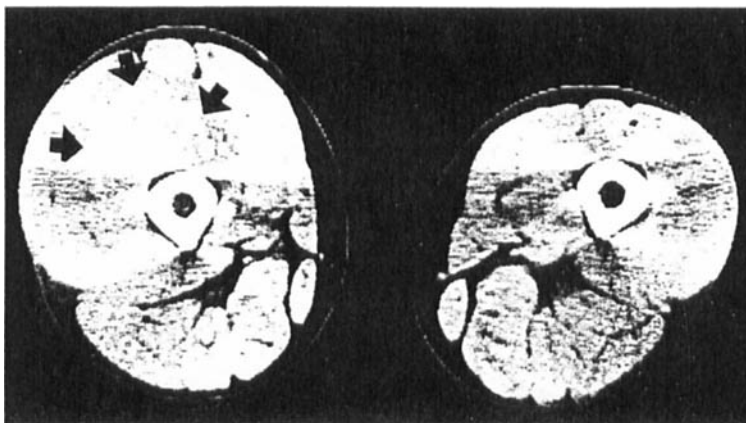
Case 1. CT 19 hours after the trauma. Hematoma in the right vastus intermedius (arrows).
